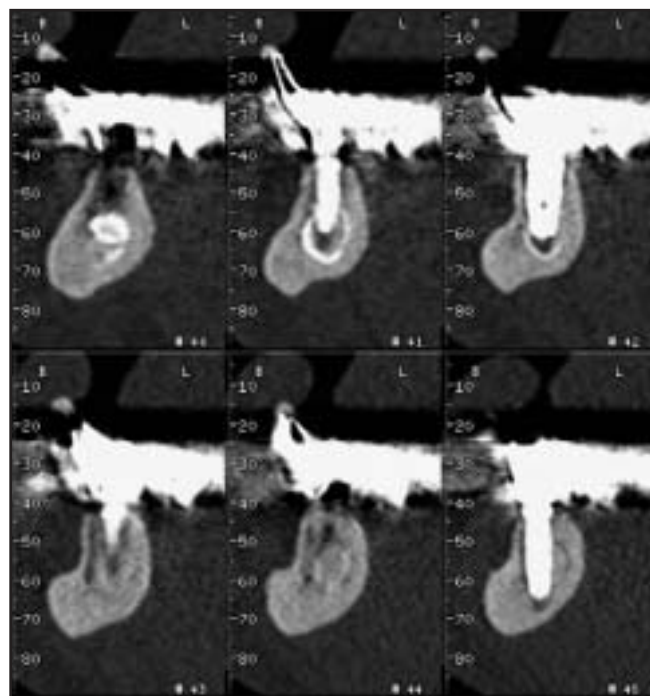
Oblique section of the CT scan at the 2-year recall confirming the impacted tooth-implant relationship. No abnormal reaction was seen at any implant, whether placed in bone or through the impacted tooth.
